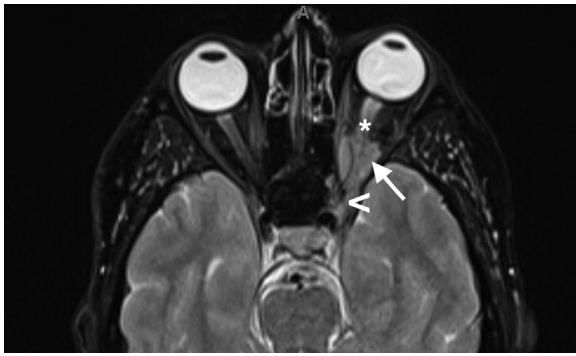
Axial T2 fat-saturated magnetic resonance imaging (MRI) without gadolinium revealed a left intraconal mass (arrow) encasing the optic nerve (*) and extending through the supraorbital fissure (arrow head) toward the left cavernous sinus.
